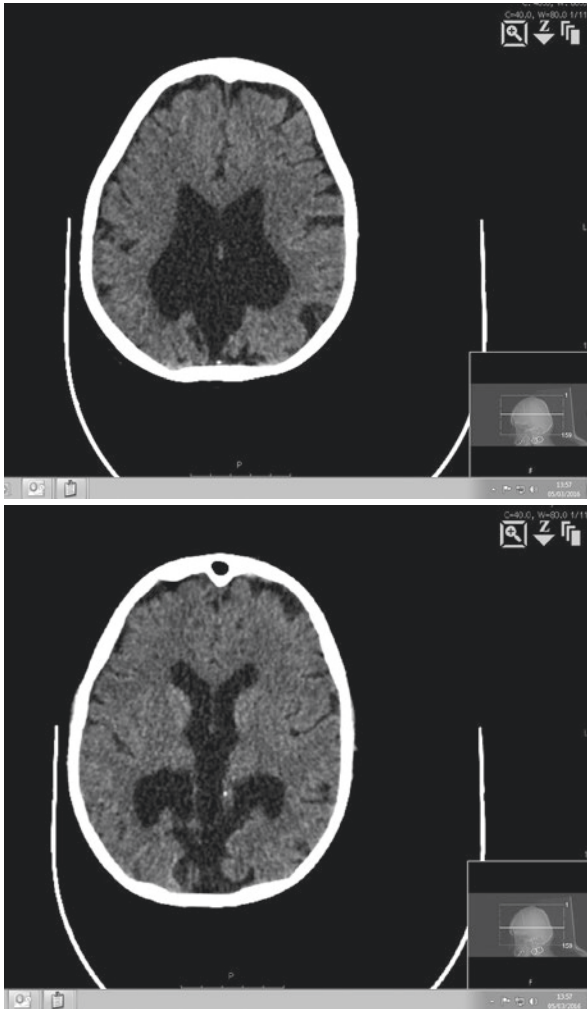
CT scan showing congenital hydrocephalus
